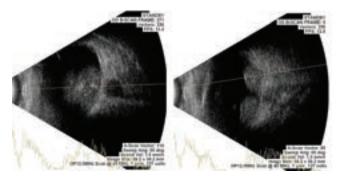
Ultrasound of each eye shows heterogenous mass-like lesions with moderate to high spikes, suggestive of calcification associated with retinoblastoma.
